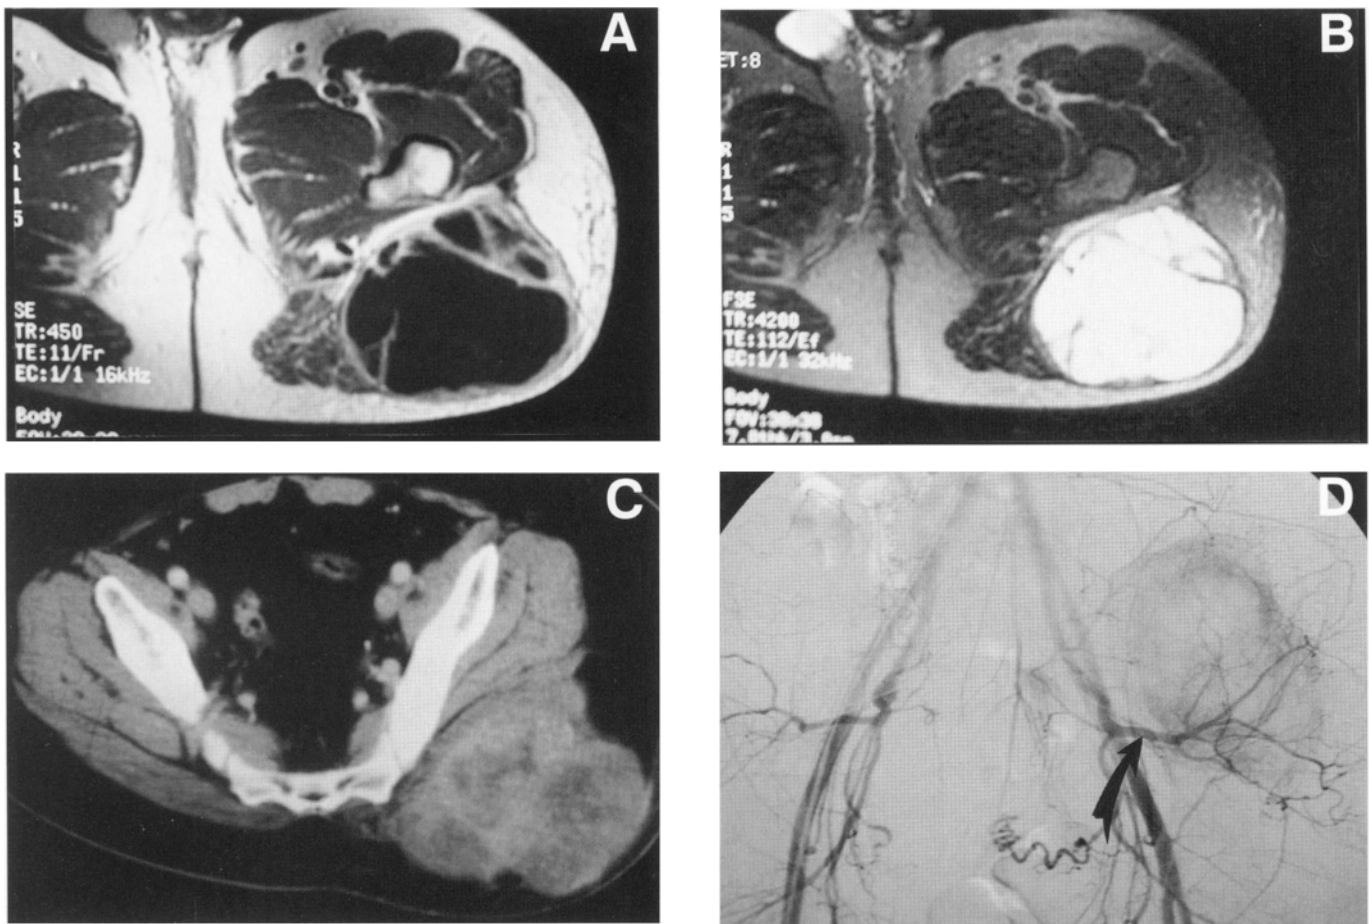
Radiographic evaluation of a patient with a large buttock sarcoma. (A, B) T1 and T2 weighted MRI images of a large buttock sarcoma. Note that on the T1 the lesion is extremely large, involving the entire gluteus maximus but without extension into the pelvis or into the anterolateral aspects of the thigh. The T2 weighted image shows a blood-filled cavity that is the result of a spontaneous bleed into the tumor following induction chemotherapy. (C) CT scan of a large buttock sarcoma involving the entire gluteus maximus but not involving the abductor muscles or showing any evidence of intrapelvic extension. (D) Late-phase angiography showing a typical tumor blush of the left buttock tumor. This represents extremely viable tumor despite induction chemotherapy. This patient was still a good candidate for a limb-sparing procedure. Note (arrow) the main vascular supply is from the gluteal vessels that supply the buttock area. These vessels are exposed and ligated early in the operative procedure.
